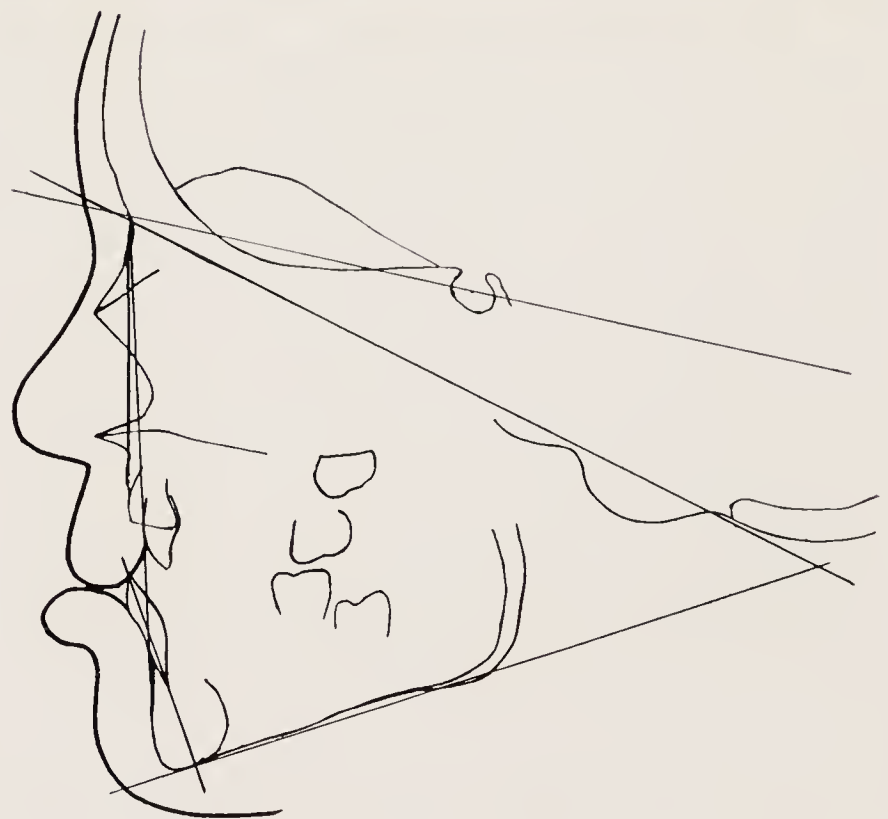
A, Arch relationship at age of 6 years in patient with unilateral complete cleft lip and palate. B, Deterioration in arch relationship in one year during change-over from temporary dentition to permanent dentition. C, Tracing of lateral skull X-ray of above patient. Adverse lip posture associated with reversed tongue action during deglutition.
